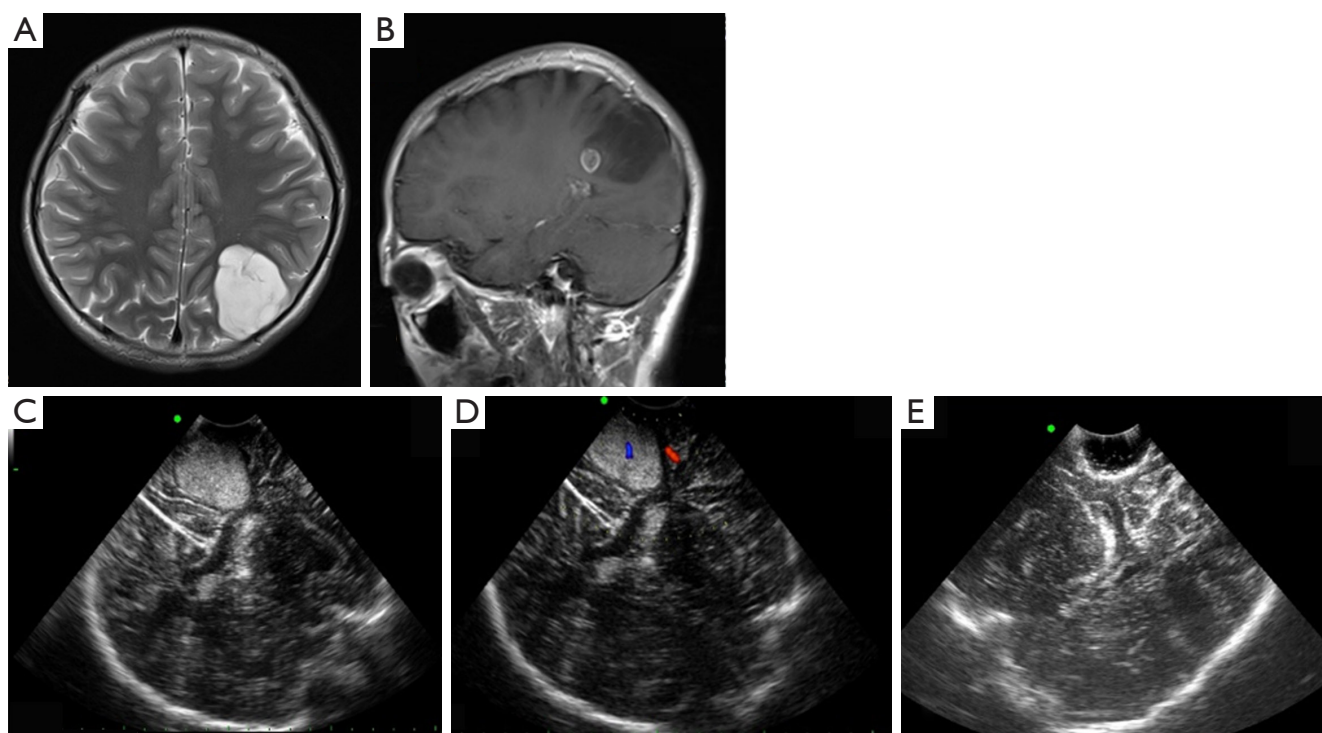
Female, 11 years old. (A,B) Preoperative MRI T1 sagittal and T2 axial images. The lesion is located in the left parietal lobe, showing patchy long T1 and long T2 with a clear boundary. Small circular enhancement in the front of the lesion can be seen on enhanced scanning. (C) IoUS shows that the lesion was located on the left side behind the corpus callosum, with a uniform, hyperechoic mass with a clear boundary. (D) Color Doppler flow imaging showed that short-strip blood flow signal can be seen in the lesion. (E) The lesion was completely removed without residue. MRI, magnetic resonance imaging; IoUS, intraoperative ultrasound.
